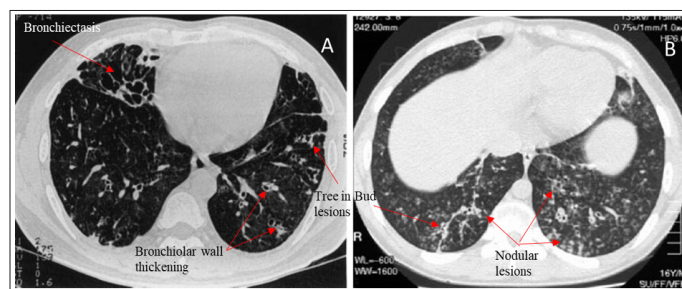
HRCT Findings in DPB Characterised by Tree in Bud Opacities, Bronchiolar Wall Thickening and Bronchiolectasis
